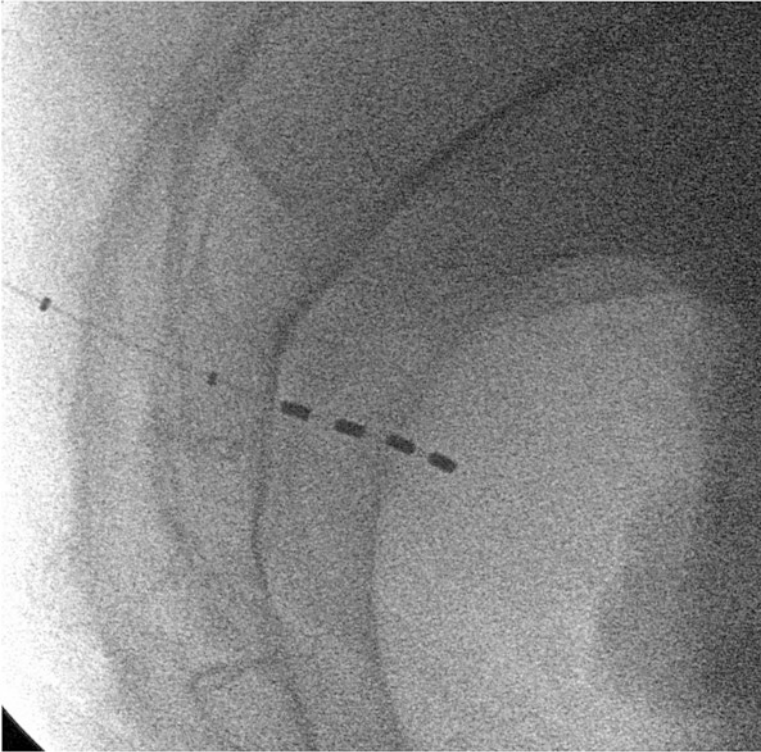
Ideal lateral x-ray. Reprinted with permission from Medtronic
